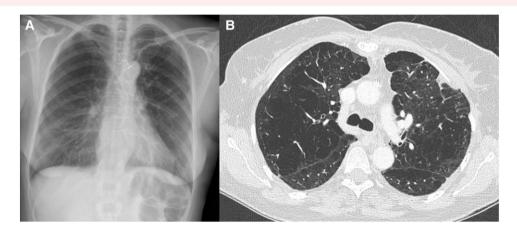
(A) Postero-anterior chest X-ray with hyperclarity in upper lobes due to emphysema (signs of chronic obstructive pulmonary disease). (B) Chest computer tomography with severe confluent type centroacinar emphysema, predominantly in upper lobes, simultaneous presence of paraseptal emphysema. Computer tomography (CT).
